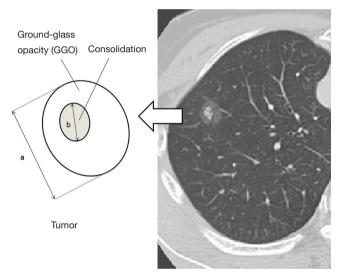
Calculation of the consolidation/tumor ratio to define radiologic noninvasive lung cancer on thin-section computed tomography. The maximum diameter of consolidation (b) is divided by the maximum tumor diameter (a) to give the consolidation/tumor ratio.
